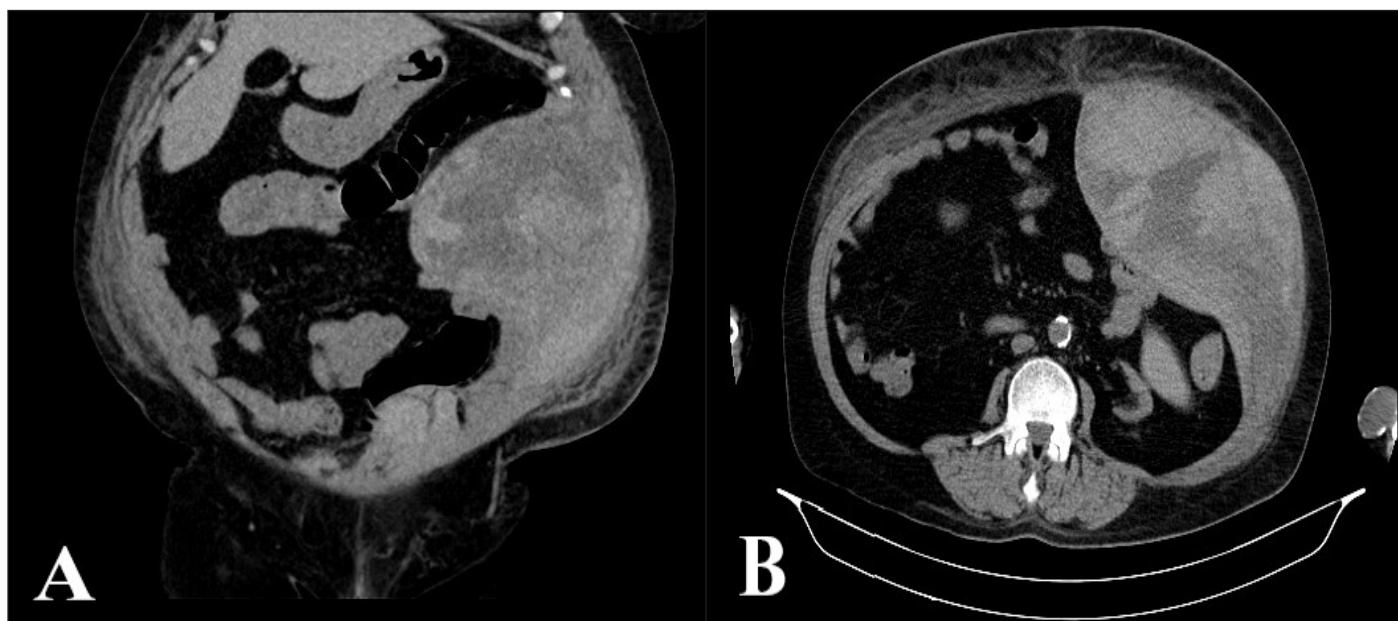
(A) Transverse computed tomography section and (B) coronal computed tomography section of the abdomen. An intramuscular hemorrhage in the left rectus muscle, which measures at 10×10×6 cm and extends into the lower abdomen and extraperitoneal space without active contrast extravasation.
